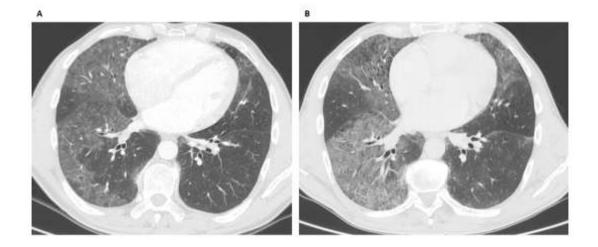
Amiodarone-induced interstitial lung disease. 48-year-old man with atrial fibrillation. Lung window images from axial CT show extensive ground glass opacities identified after two years of treatment with amiodarone (A). After one year, despite drug discontinuation and initiation of glucocorticoids, ground glass opacities became more extensive (B).
